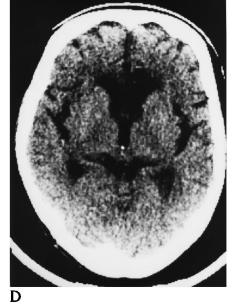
CT and MR images, 3 months after onset.
